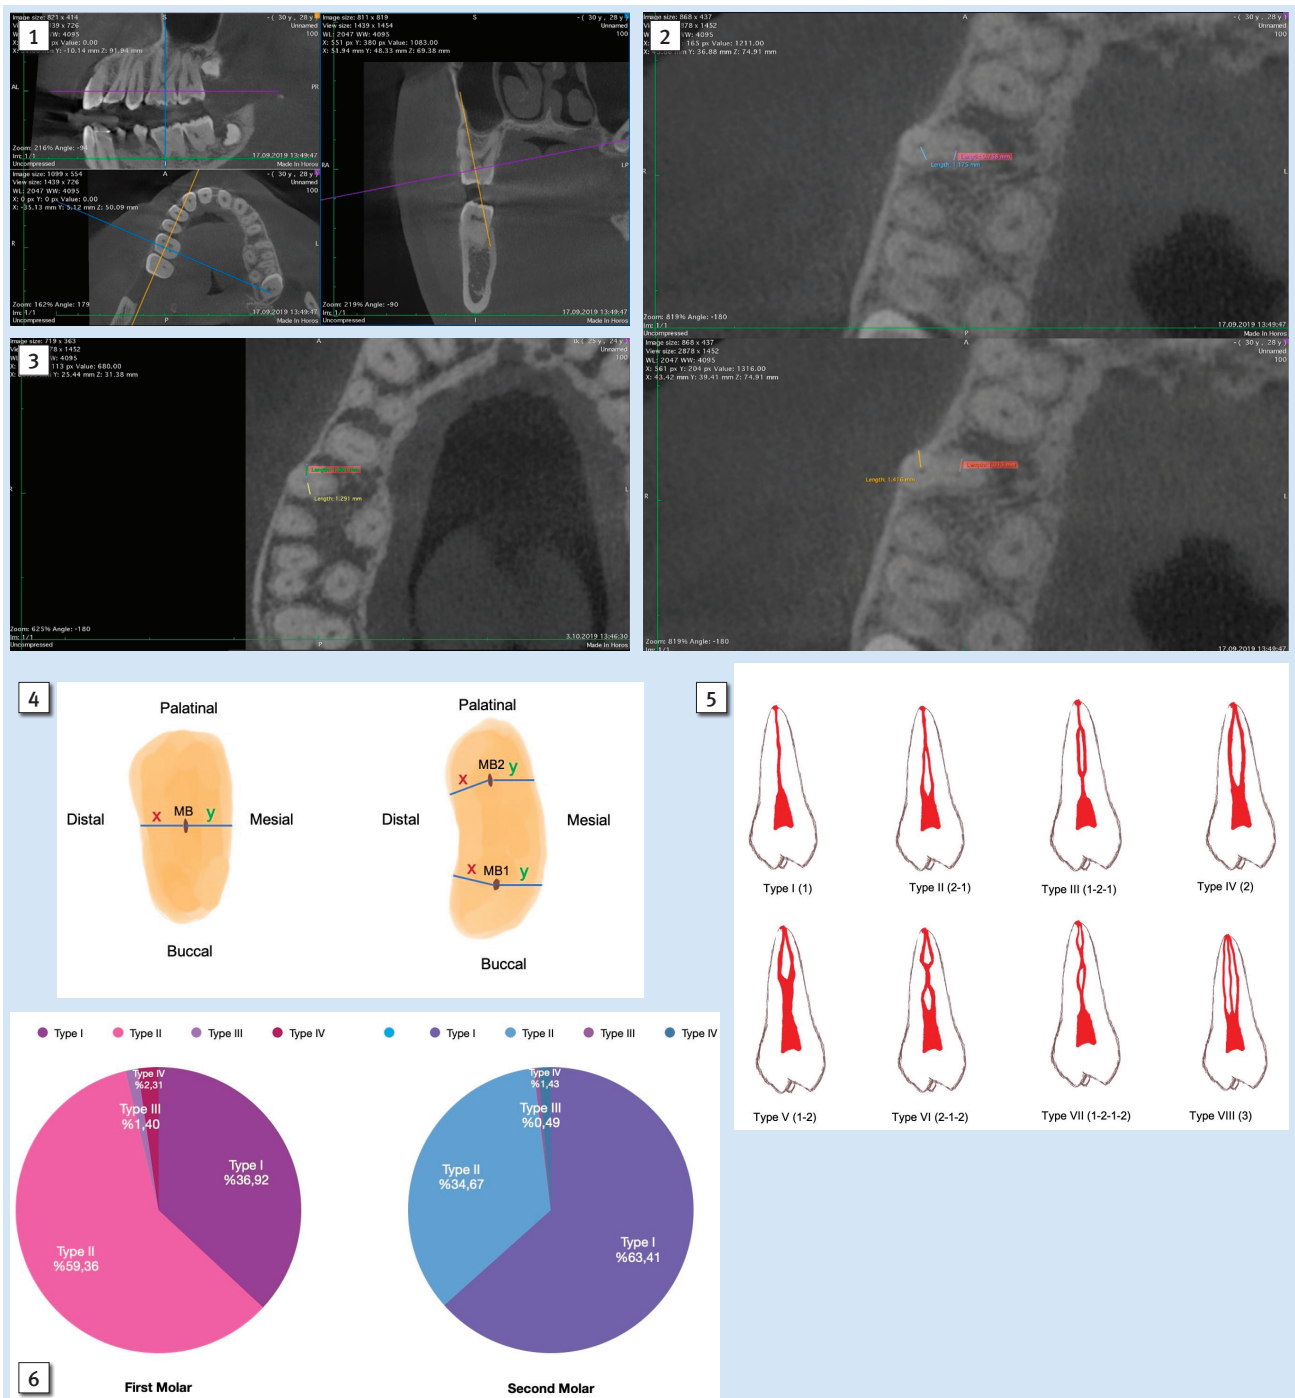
CBCT images for each maxillary molar individually in sagittal (upper left), axial (lower left), and coronal (right) planes.
